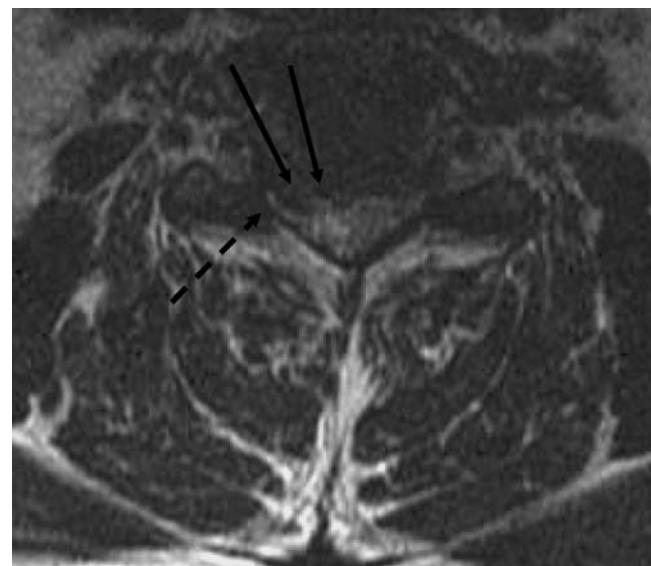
Axial T2-weighted sequence MRI showing narrowing of the right intervertebral foramina (dashed arrow) and cord compression at the level of C5-6 (arrows).
